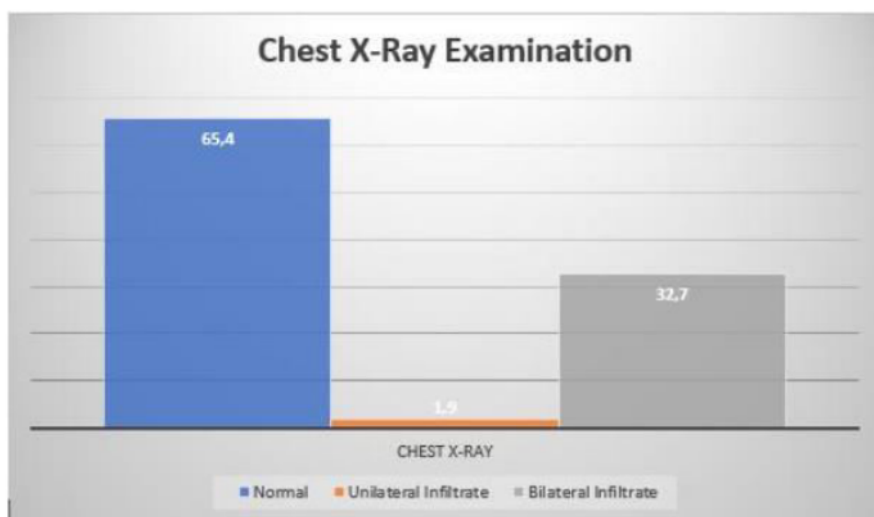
Chest X-Ray Percentage of COVID-19 Patients
